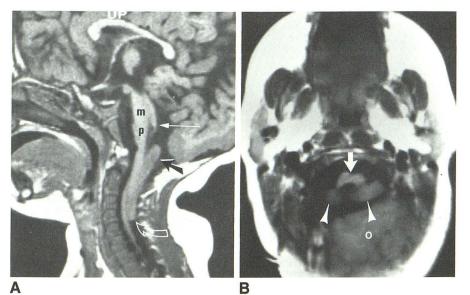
17-month-old girl born with lumbar meningomyelocele closed at birth. Episodes of stridor and cyanosis on crying were noted at the age of 1 week. At the time of the MR image her chest showed inspiratory stridor and she also had a left sixth nerve palsy. The motor movement and coordination of the upper extremities were poor with slightly depressed reflexes. The knee jerks were present but the ankle jerks were absent.
